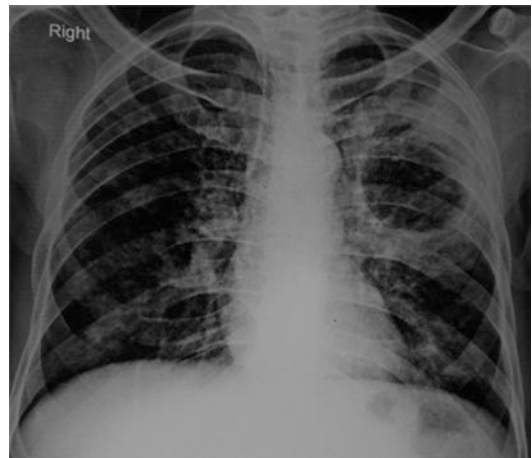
A posteroanterior chest radiograph showing a large thick-walled cavitary lesion in the left upper and mid zone. Sputum examination demonstrated aseptate hyphae suggestive of Mucormycosis
